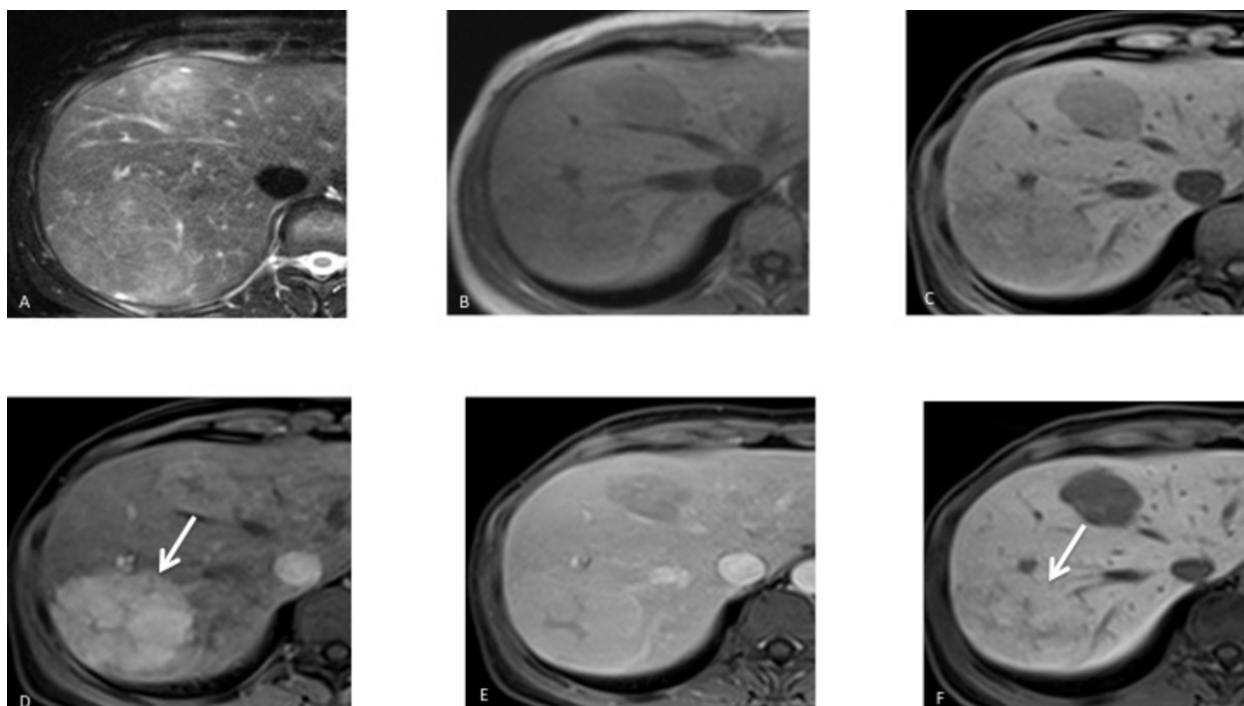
46-year-old woman with focal nodular hyperplasia (FNH) and HNF-1 β -mutated hepatocellular adenoma (HHCA). FNH (arrow) almost always appears as a homogeneous, markedly hypervascular mass on arterial-phase images (D) with a central scar that is hypointense and HHCA appears with a moderate arterial enhancement. The scar typically appears hyperintense on T2-weighted MR images (A). On portal venous-phase (E) focal nodular hyperplasia is usually nearly isointense relative to liver and the HHCA show washout. HB phase gadolinetic acid-enhanced MR image shows that the FNH (arrow) is isointense to surrounding liver and HHCA is hypointense. A - Axial T2-weighted fat-saturated imaging; B - Axial T1-weighted imaging; C - Axial T1-weighted fat-saturated imaging; D, E and F - Contrast-enhanced T1-weighted MR images in arterial phase (D), portal venous phase (E) and HB phase gadolinetic acid-enhanced MR image.
